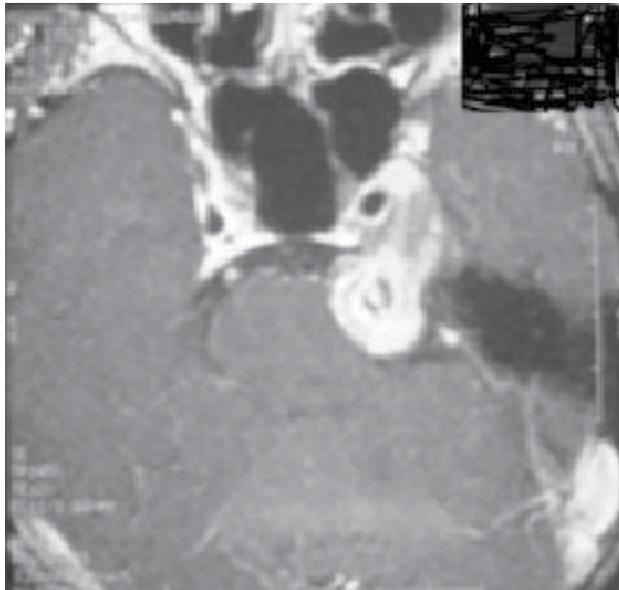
Axial post contrast MRI of patient with left sided facial pain who was found to have a small trigeminal neuroma compressing the trigeminal nerve.
